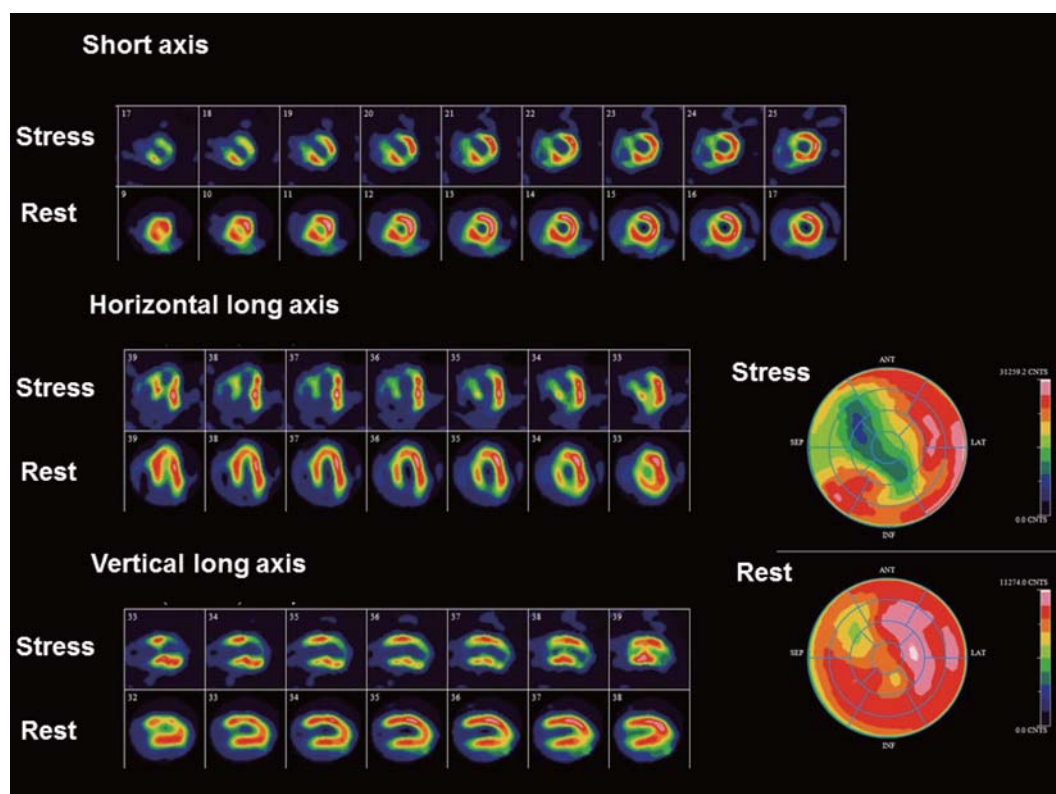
A representative case with exercise SPECT-MPI
